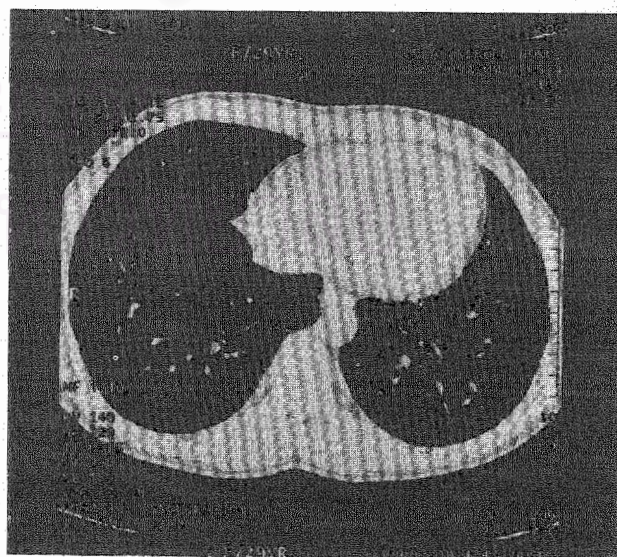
High resolution CT scan (HRCT) picture of Case No. 2, showing diffused interstitial thickening and fibrotic pleura.
